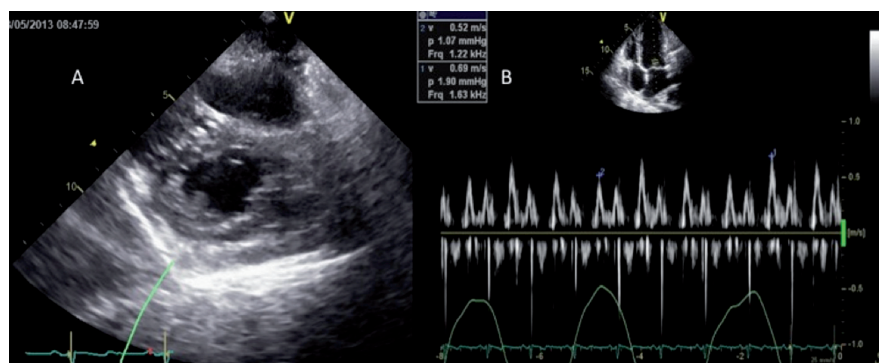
Panel A, two dimensional echocardiographic view of interventricular septal bounce suggestive of constrictive pericarditis. Panel B, significant extent of respiratory variation in mitral inflow E velocity.
